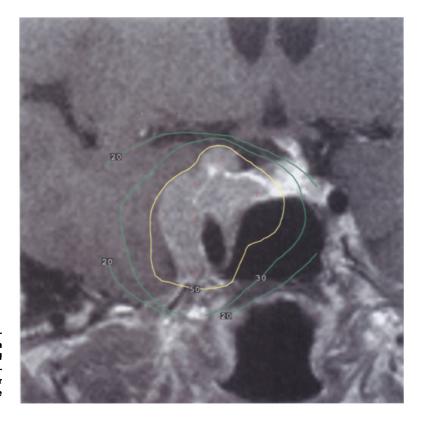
A 51-year-old woman had a large nonsecreting pituitary adenoma residual at operation with extension in the right cavernous sinus. MRI coronal reconstruction with overimposed treatment plan outline shown. Treatment has been prepared to deliver 15 Gy at the 50% isodose curve. The 20% isodose curve (6 Gy) is outside the optic chiasm.
